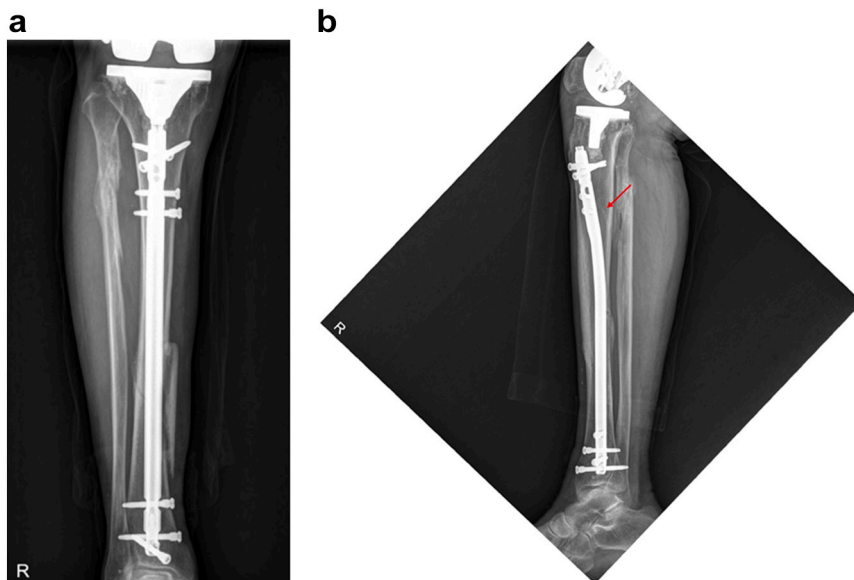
Six-month follow-up simple radiographs demonstrating healing of the fracture. (A) Anteroposterior and (B) lateral images.
